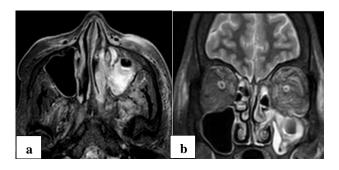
T2W FS MRI PNS (a) axial section reveals heterogeneous altered signal intensity soft tissue lesion involving the maxillary sinus infiltrating the periantral buccal space, and (b) coronal section reveals heterogeneous altered signal intensity involving the left maxillary, ethmoid, and left nasal cavity with hypointense areas within.
